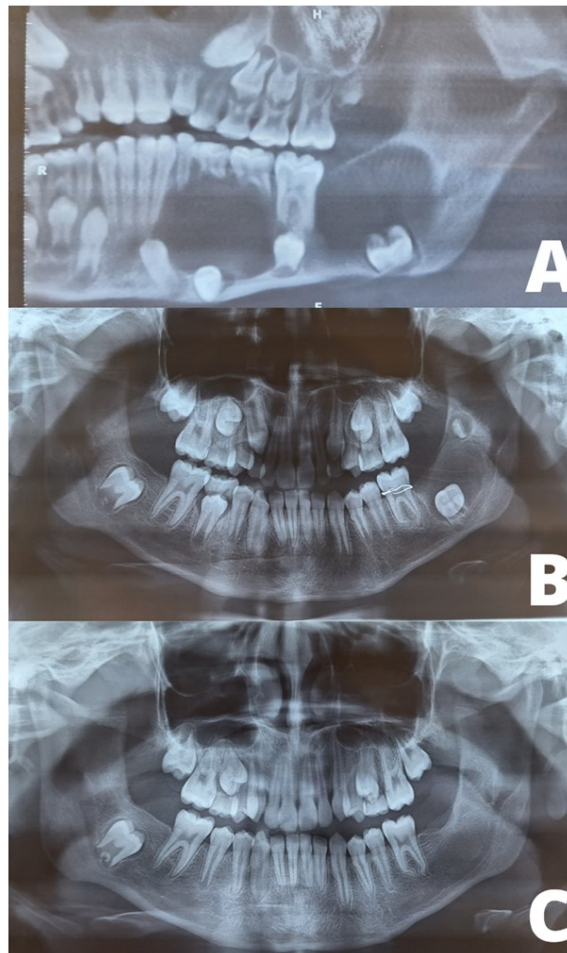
Evolution of the patient, initial panoramic view (A), injury to the left mandibular body after decompression (B) and control x-ray two years later, where no new injuries are observed (C).
